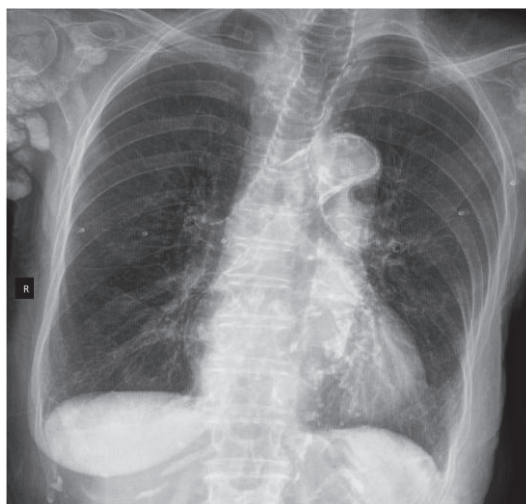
Chest X-ray (face radiography):
